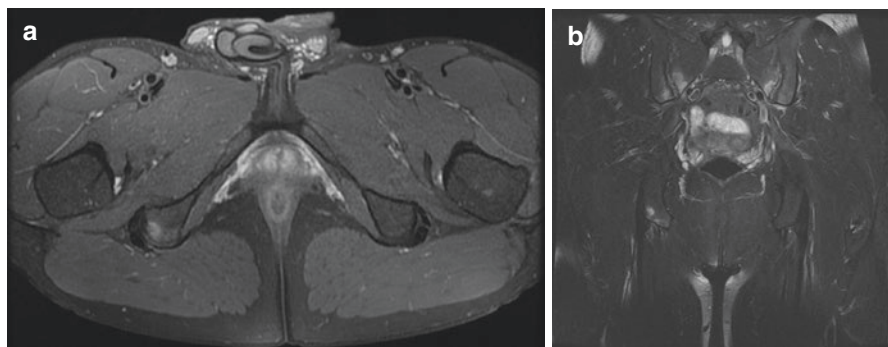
Magnetic resonance imaging (MRI) of a hamstring tendinopathy and sacroiliitis caused by spondyloarthropathy. Panel (a) is an axial T2-weighted MR image that demonstrates right-sided increased signal intensity of the ischial tuberosity which is indicative of a bony cyst. There is also an increased thickness of the hamstring tendon origin. Panel (b) is a coronal T2-weighted MR image of the pelvis revealing increased signal intensity along the sacroiliac joints in the same patient. Based on the patient's history and abnormalities on this MRI, this abnormality was interpreted as enthesitis and sacroiliitis caused by a spondyloarthropathy
